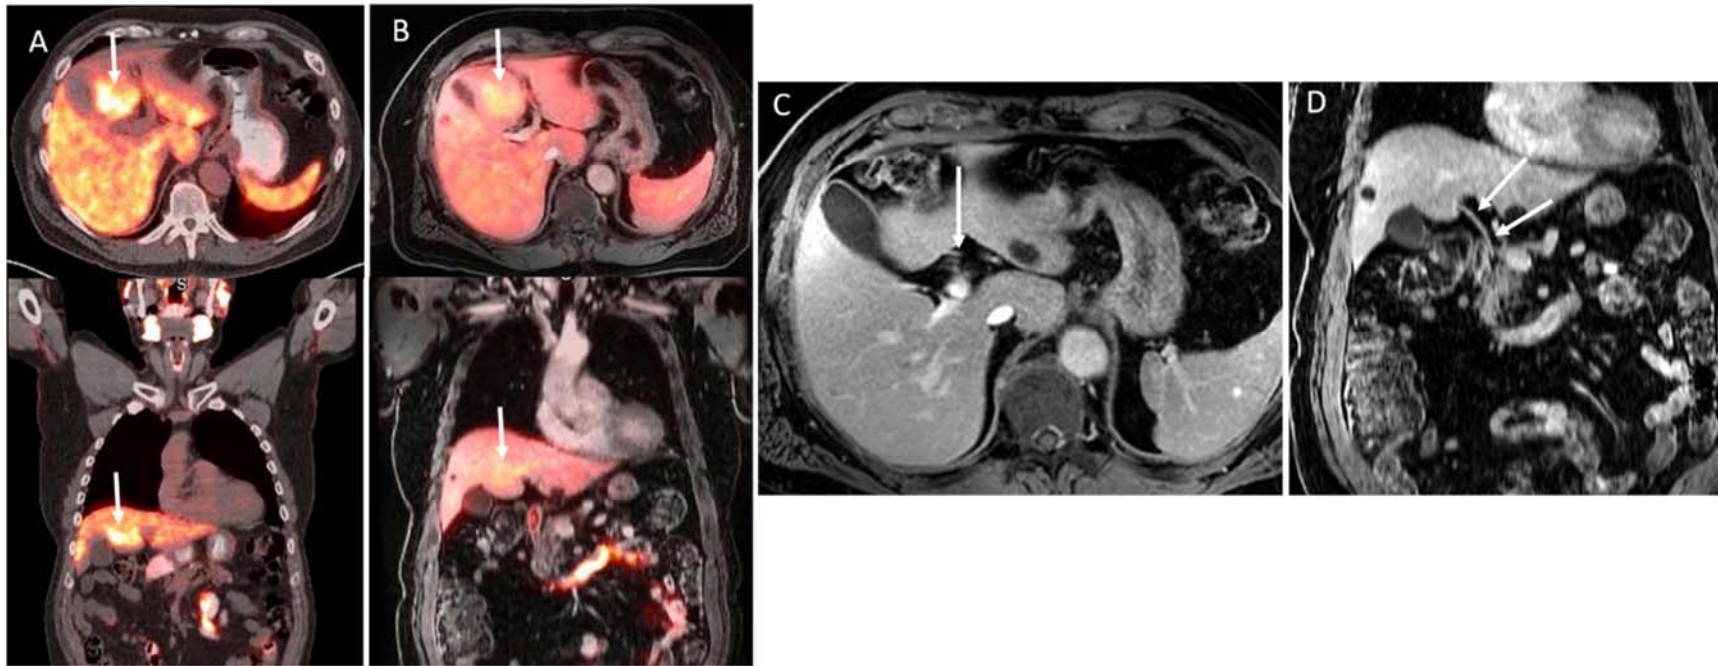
Case 1: A 75-year-old man with prostate cancer (PCa) post radical prostatectomy (Gleason 5+5). ^{68}Ga -PSMA PET/CT (fused trans-axial and coronal PET/CT images - A) done in November 2022 for localizing recurrence at a PSA of 0.57 ng/mL showed focal intense radiotracer avidity in liver segment IVb (arrows) and a solitary site of disease recurrence in L3 vertebra (not shown). A prior ^{18}F -DCFPyL (Pylarify) PET/MR (fused trans-axial and coronal PET/MR images - B) done after post-surgical radiotherapy in March 2022 at a PSA of 0.01 ng/mL also show increased radiotracer accumulation in the same region. Interestingly, review of the MR images showed an aberrant vessel entering hepatic segment IV (arrow; trans-axial MR - C) on axial post-contrast T1FS sequence without any hepatic parenchyma anomaly in the region. The coronal post-contrast T1FS sequence (D) demonstrates the aberrant vessel arising from the duodenum/pancreatic head and terminating within hepatic segment IV (arrows-D). Avidity on PSMA-targeted PET imaging has been widely reported in multiple non-prostate neoplastic, and non-neoplastic conditions, including cancer therapy-related injuries.¹⁻³ PSMA avidity due to aberrant vascular anatomy has not been widely reported. This case highlights many important lessons, including the consistency of this artifactual uptake with different PSMA-targeting radiopharmaceuticals, and across different imaging techniques.
